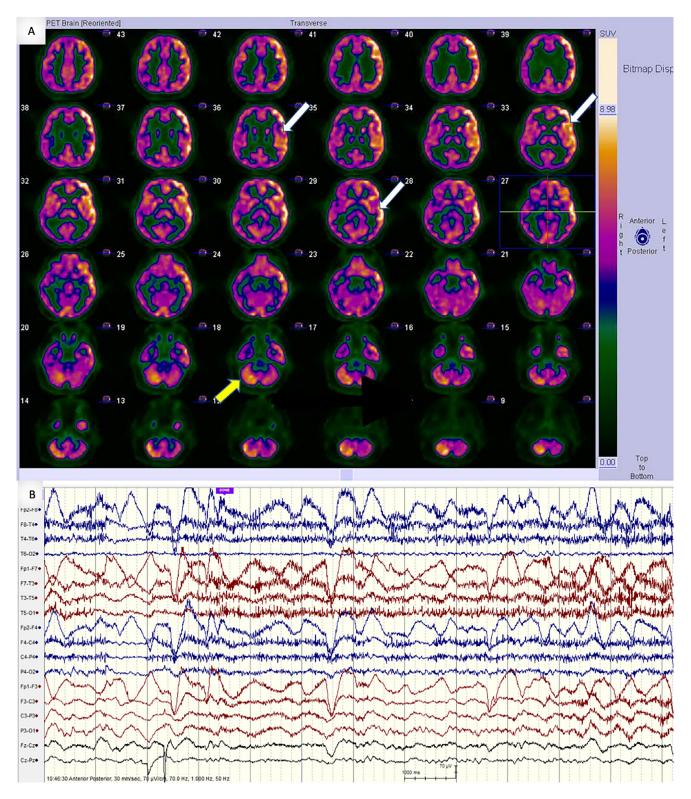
Ictal findings: (A) FDG-PET scan showing left fronto-temporal, parietal (white arrows) and crossed cerebellar hypermetabolism (or diaschisis, yellow arrow). (B) EEG during FDG uptake showing continuous left fronto-temporal semi-rhythmic delta activity. Clinically patient was mute and only following simple commands (Color version of the figure is available online.)
